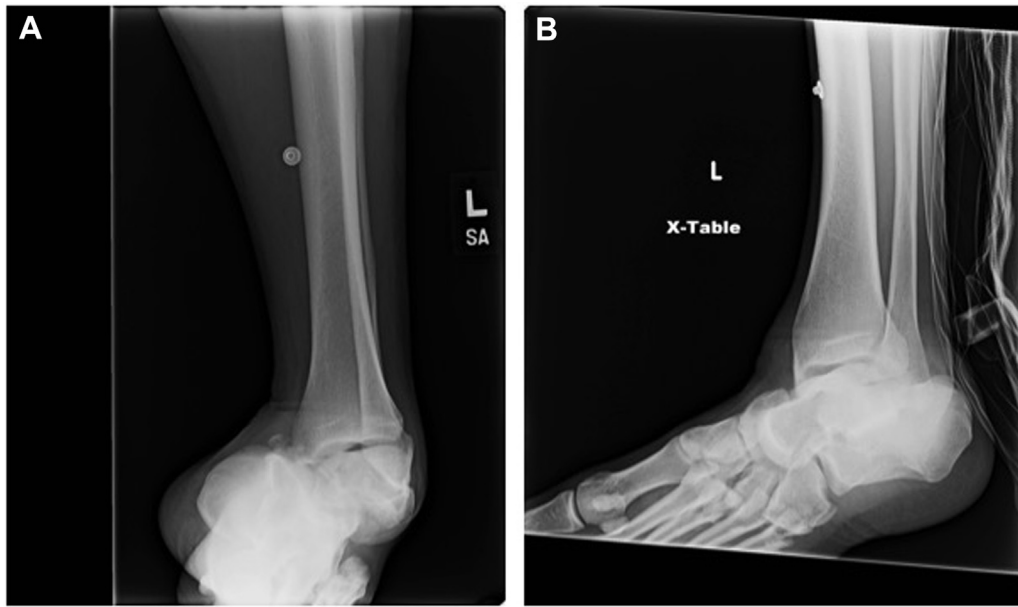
(A) A radiograph of the left ankle revealing a medial subtalar dislocation and multiple foot fractures including a medial malleolus fracture. (B) A radiograph of the left ankle revealing a medial subtalar dislocation and multiple foot fractures including a medial malleolus fracture.
